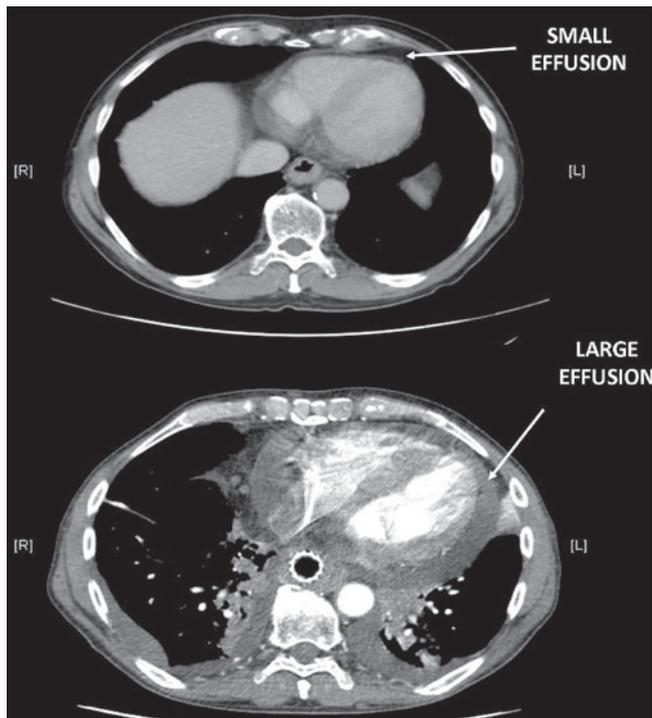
Two standard transverse CT slices demonstrate a small and a large effusion. Note the attenuation characteristics of the effusion. Images courtesy of Radiology Department, John Radcliffe Hospital, Oxford
